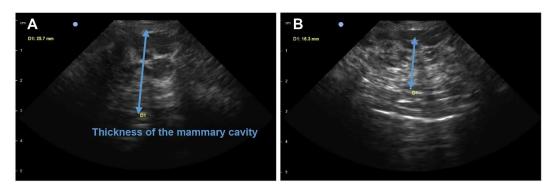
Ultrasound image of the mammary cavity.
